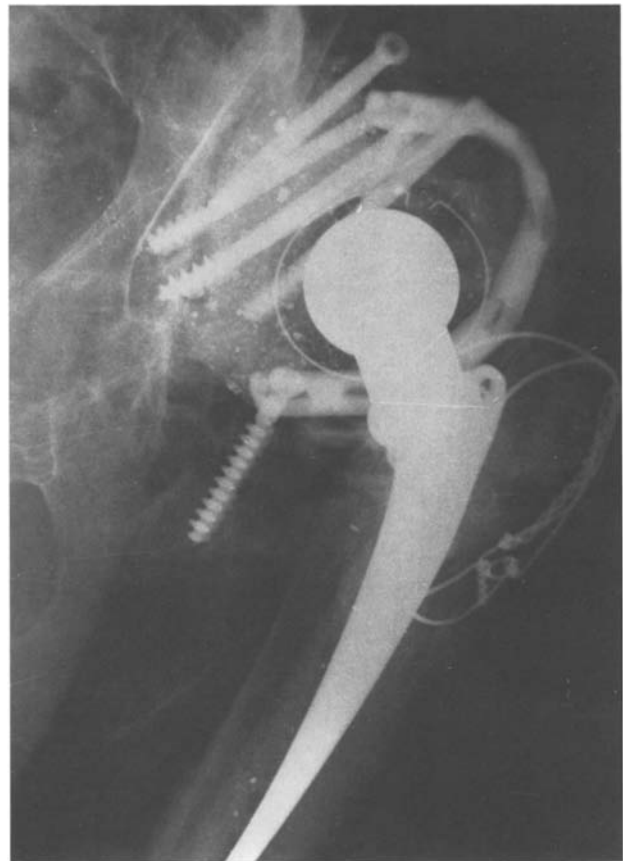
The so-called obturator X-ray examination reveals the extent of the loosening
